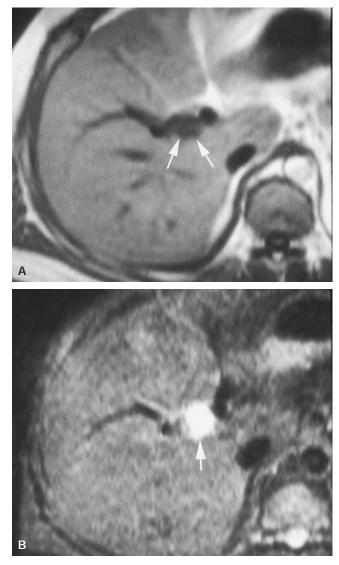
A*, Magnetic resonance visualization of a metastatic gastrinoma in the liver (*white arrows*). In *B*, the same lesion is seen on computed tomographic scan (*white arrow*). The magnetic resonance image was obtained before contrast administration.
